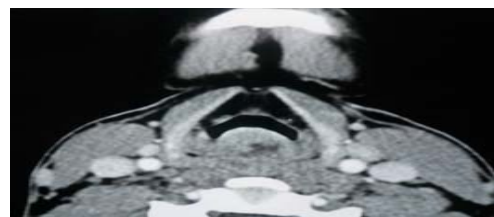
CT image axial section showing well encapsulated isodense mass arising from posterior pharyngeal wall
